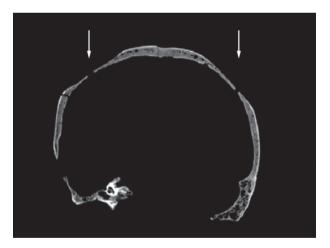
CT coronal vision, symmetrical depression of the parietals whit resorption of the external table and the diploe.
